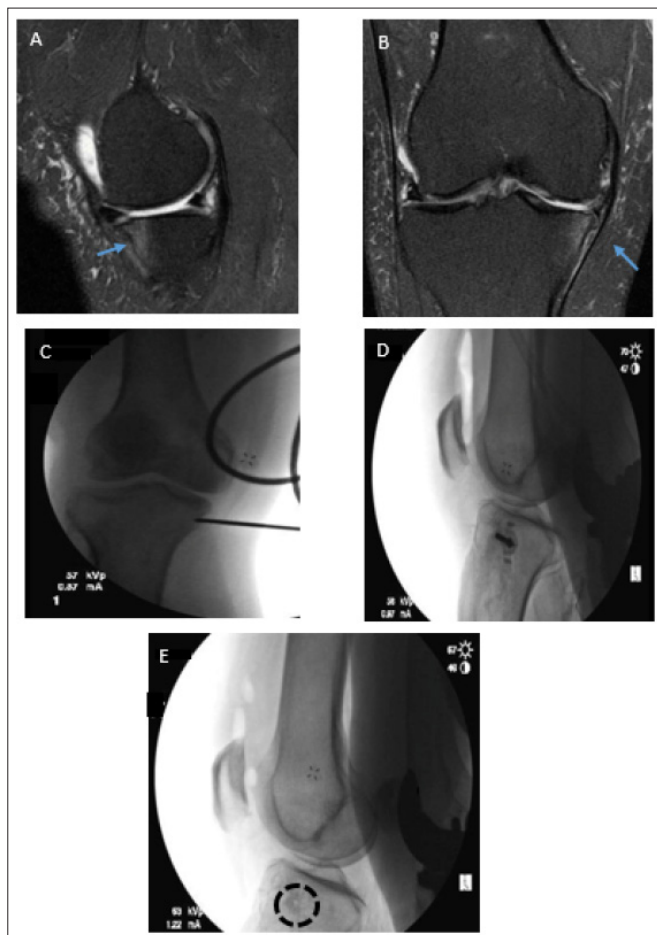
Bone marrow lesions on MRI and intraoperative fluoroscopic images. (A) Sagittal T2 Fat Sat MRI demonstrating bone marrow lesion (arrow) in anterior proximal tibial plateau. (B) Coronal T2 Fat Sat MRI demonstrating bone marrow lesion (arrow) in medial tibial plateau. (C) Intraoperative AP fluoroscopic image demonstrating placement of cannula in medial tibial plateau. (D) Intraoperative lateral fluoroscopic image with cannula injecting BSM. (E) Intraoperative Lateral fluoroscopic Image after injection of BSM (diffuse gray-shaded region within highlighted circle) into the medial tibial plateau.
